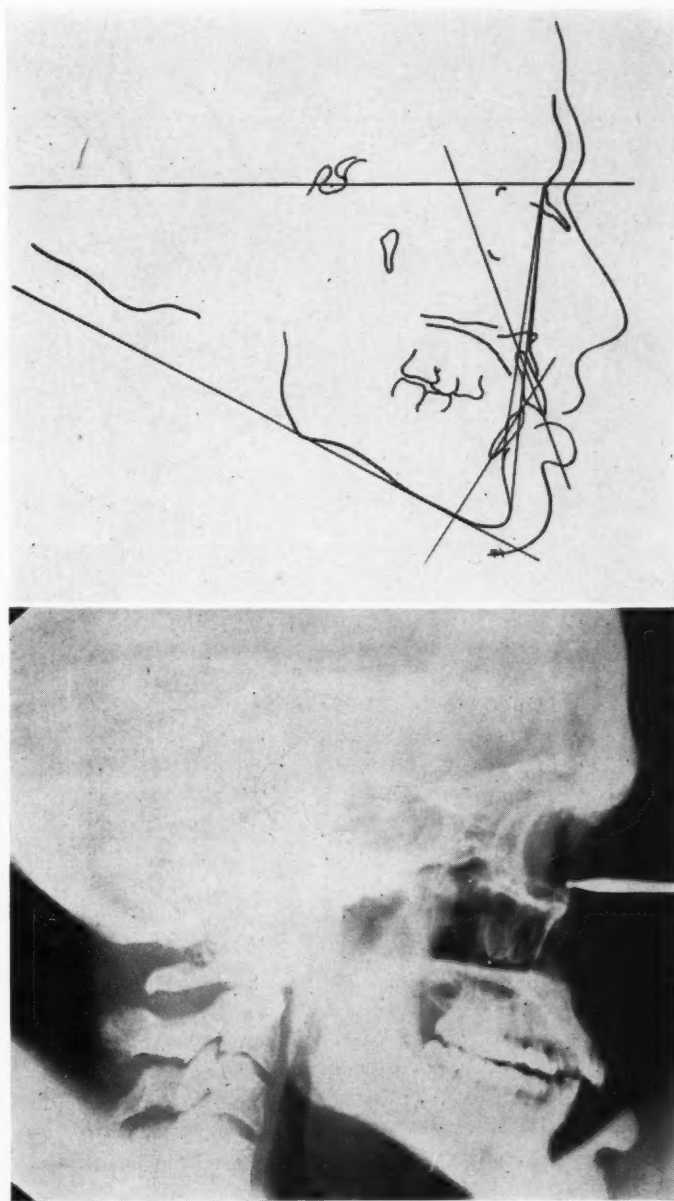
Patient W. S. Cephalometric radiograph and tracing in approximate centric occlusion.
